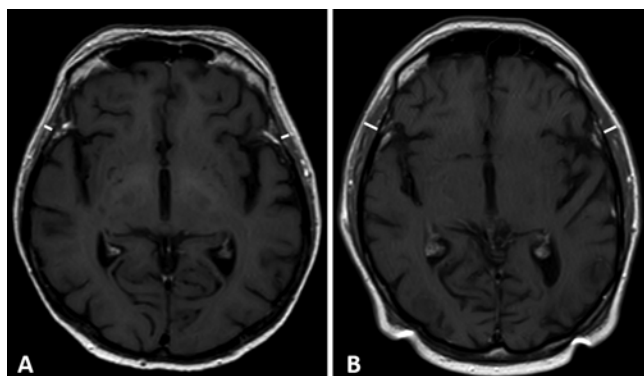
TMT measurements on axial contrast-enhanced T1-weighted MR images from 2 female NSCLC patients with BMs. A: Image obtained in a 72-year-old female patient with a mean TMT of 2.9 mm (below the sex-specific cutoff value) and a survival duration of 23.0 months after GKRS1. B: Image obtained in a 70-year-old female patient with a TMT of 5.4 mm and a survival duration of 43.0 months after GKRS1. To avoid any potentially influencing factors, 2 patients with similar baseline characteristics (adenocarcinomas, age > 65 years, KPS > 80%, multiple BMs, no ECMs, negative oncological markers, GPA/RPA/SIR classifications, and no previous oncological treatments before or at GKRS1) were chosen.
